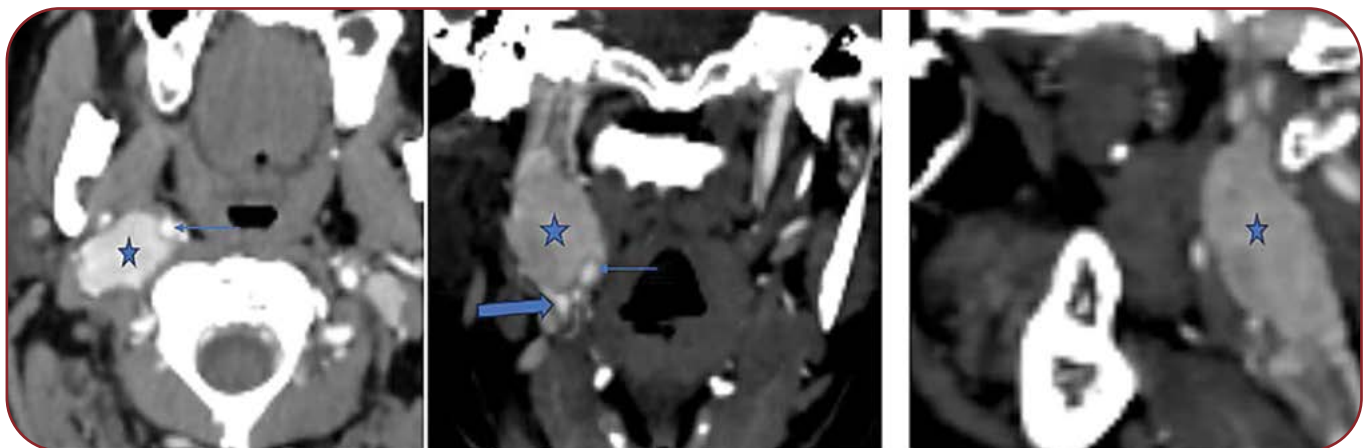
Case 1: carotid body paraganglioma. Computed tomography (CT) angiography neck axial and sagittal images showing a well-defined intensely enhancing lesion (star) epicentered in the right carotid sheath at the carotid bifurcation. The right internal carotid artery (ICA) (thin arrow) is seen along the medial aspect of the lesion. Coronal images show the lesion splaying the ICA (thin arrow) and external carotid artery (ECA) (thick arrow).
